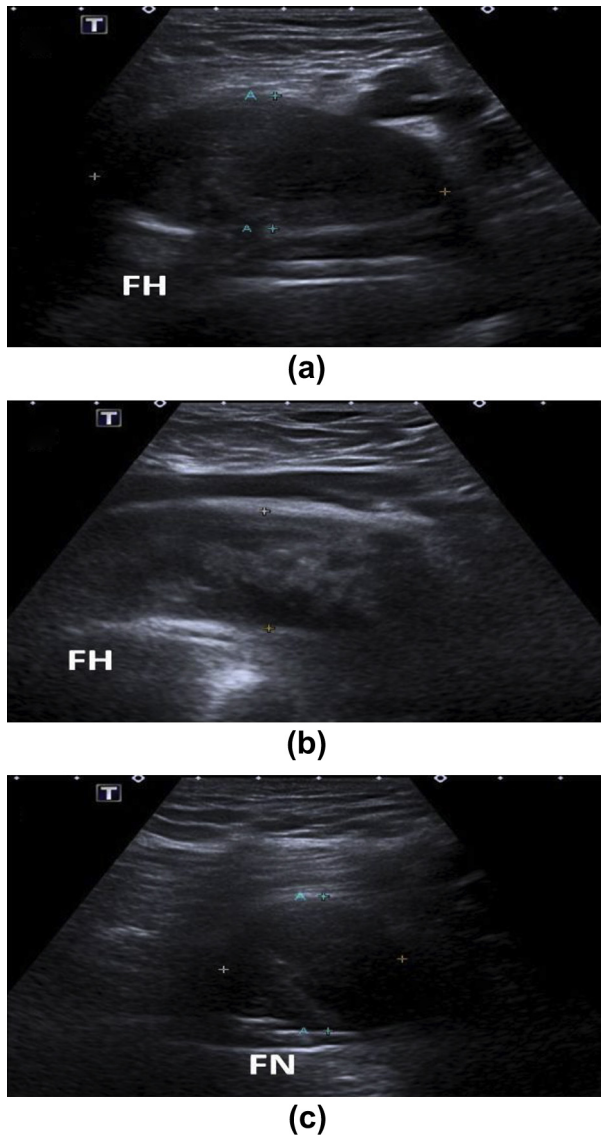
Complex type 3 pseudotumours [cranial aspect to left of image (a) and (b)]. Ultrasound images of type 3 pseudotumours with a complex internal echo-texture (predominantly solid), showing (a) a right anterior pseudotumour in longitudinal section; (b) a left anterior pseudotumour in longitudinal section; and (c) a left posterior pseudotumour in transverse section. FH, femoral head; FN, femoral neck.
